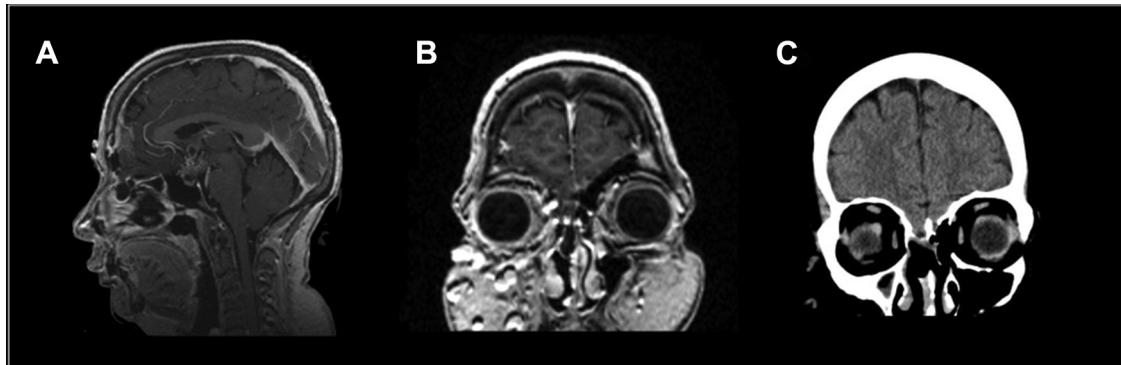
Preoperative gadolinium-enhanced (A) sagittal and (B) coronal brain magnetic resonance imaging and (C) coronal computed tomography scan demonstrating a chiasmatic arteriovenous malformation and a right-sided
